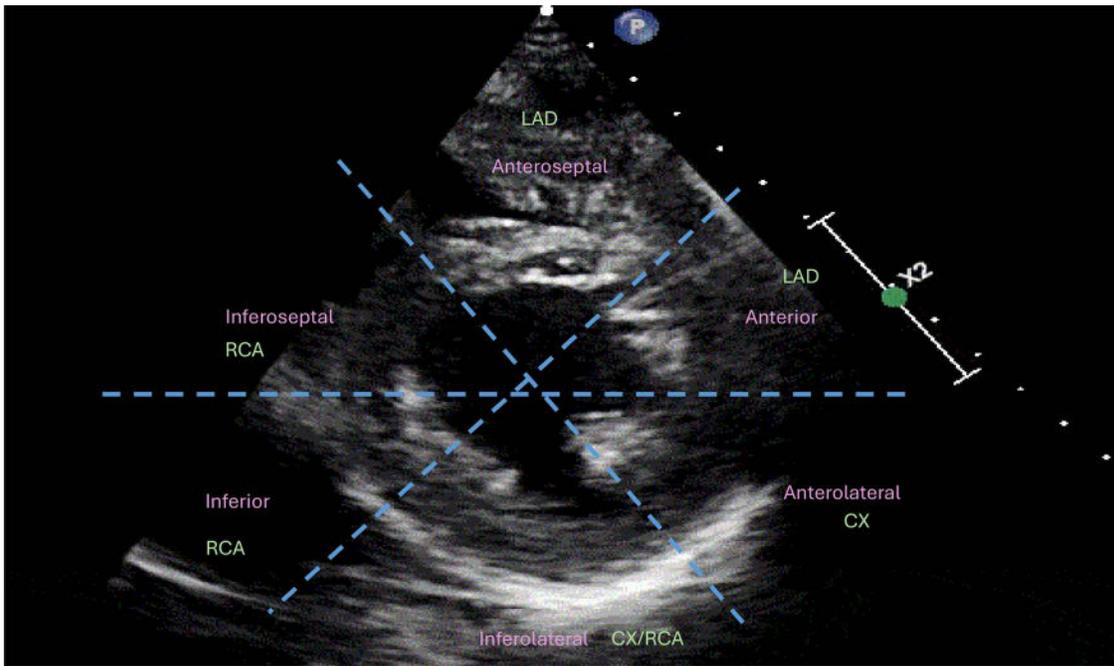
Parasternal short-axis (PSAX) with left ventricular (LV) walls labelled with most common blood supply pattern.
